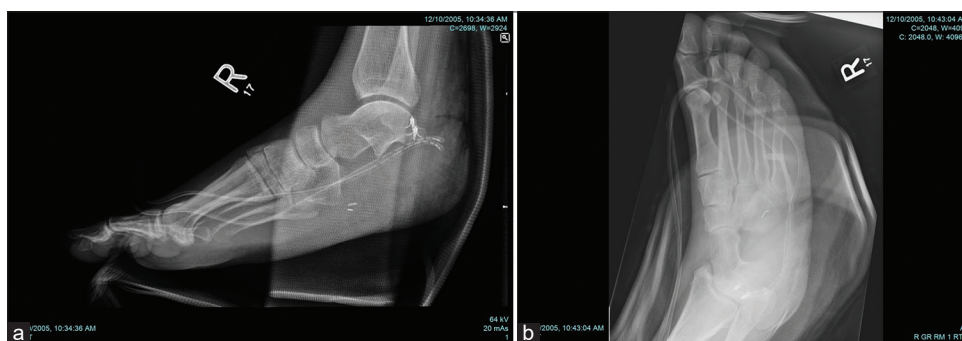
Post-operative radiographs showing absent calcaneum, Mitek sutures in talus for reconstruction of Achilles tendon and a back slab in equinus. (a) Lateral view and (b) Anteroposterior oblique view.
